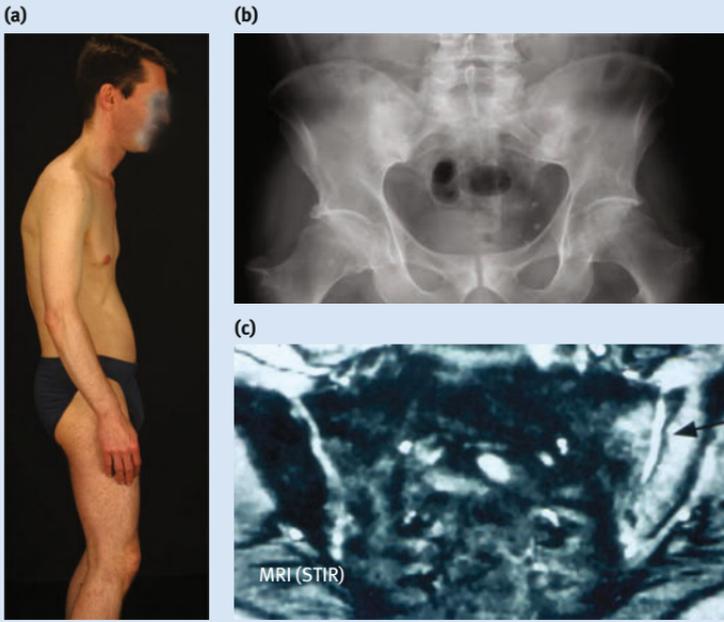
Historical aspects of AS. AS, ankylosing spondylitis; MRI, magnetic resonance imaging; STIR, short tau inversion recovery. (a) in the 1900s a diagnosis could only be made when the patient exhibited the typical posture associated with AS; (b) a radiograph showing bilateral sacroiliitis - roentgenology began to be applied to AS in the 1930s; (c) a magnetic resonance image showing a patient with acute sacroiliitis – the use of MRI in the early 1990s helped to identify the presence of an inflammatory non-radiographic stage early in the course of AS.
